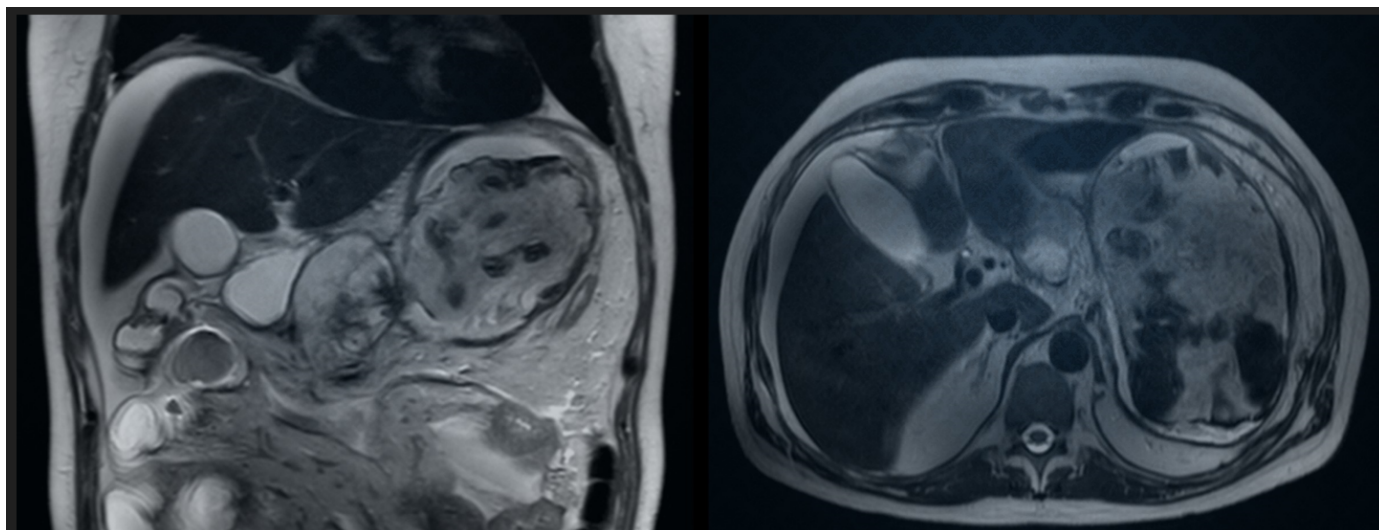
MRI examination from January 2017
